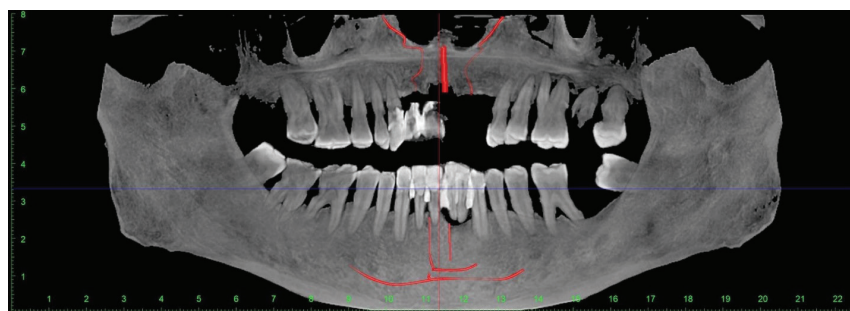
CBCT for planning
